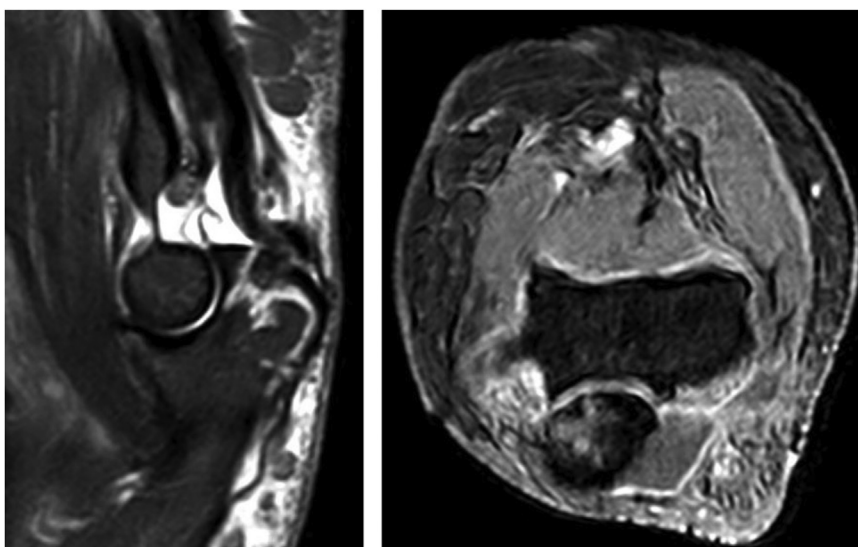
Sagittal short tau inversion recovery MRI left and postcontrast axial view right 14 months from index procedure with evidence of postsurgical changes and without evidence of nodular enhancement within the surgical bed to suggest recurrent tumor. MRI, magnetic resonance imaging.
